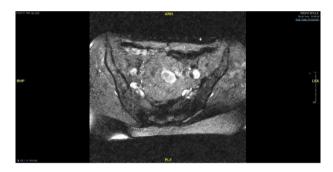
MRI of the pelvis (FSAT T1 TRS).
